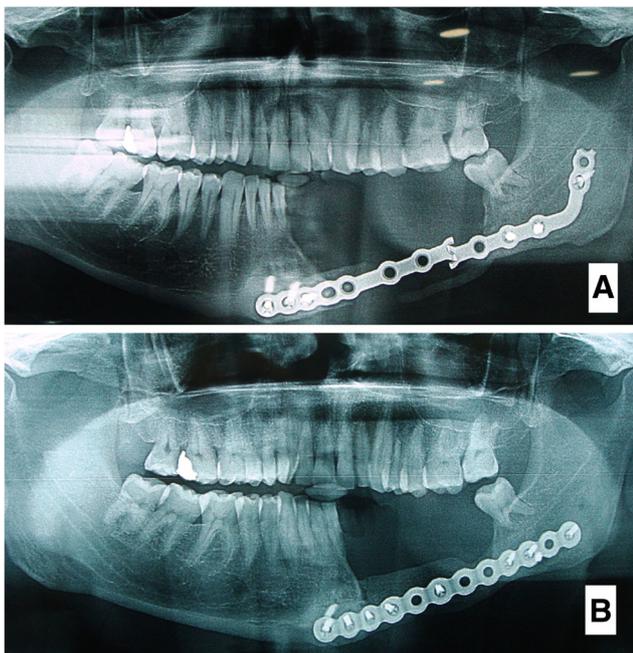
a Panoramic radiograph showing fracture of reconstruction plate without bone graft. b Panoramic radiograph of the same patient after removal of the fractured plate and reconstruction of the mandibular defect with another reconstruction plate and bone graft
